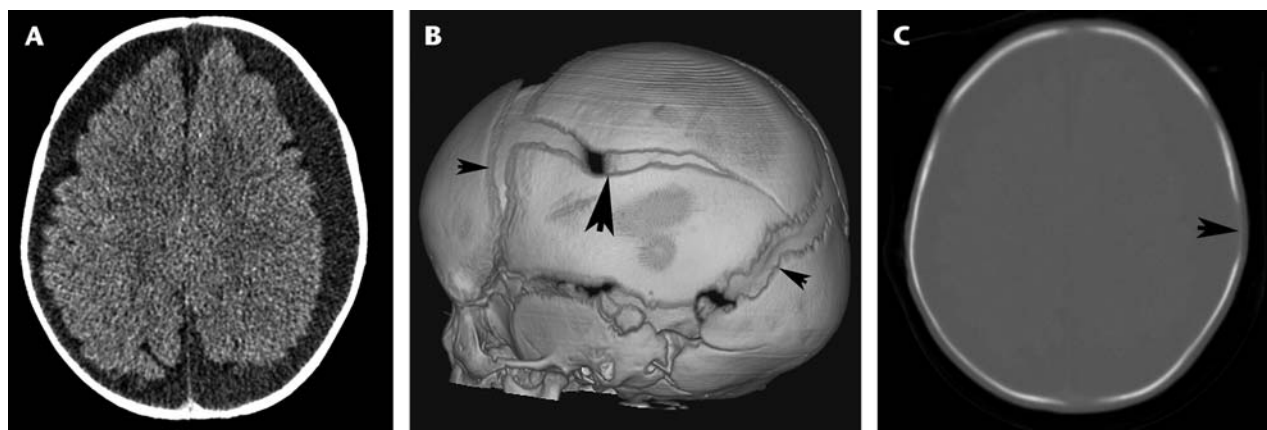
A, Axial image from a non-contrast CT in a 4-month-old infant with macrocephaly demonstrated prominent extra-axial fluid spaces. B, 3-D CT showed a large horizontally oriented left parietal fracture (large arrow) and dramatically diastatic sutures (small arrows). C, Initial bone windows had a subtle left parietal lucency (arrow), not initially recognized to be a fracture.
